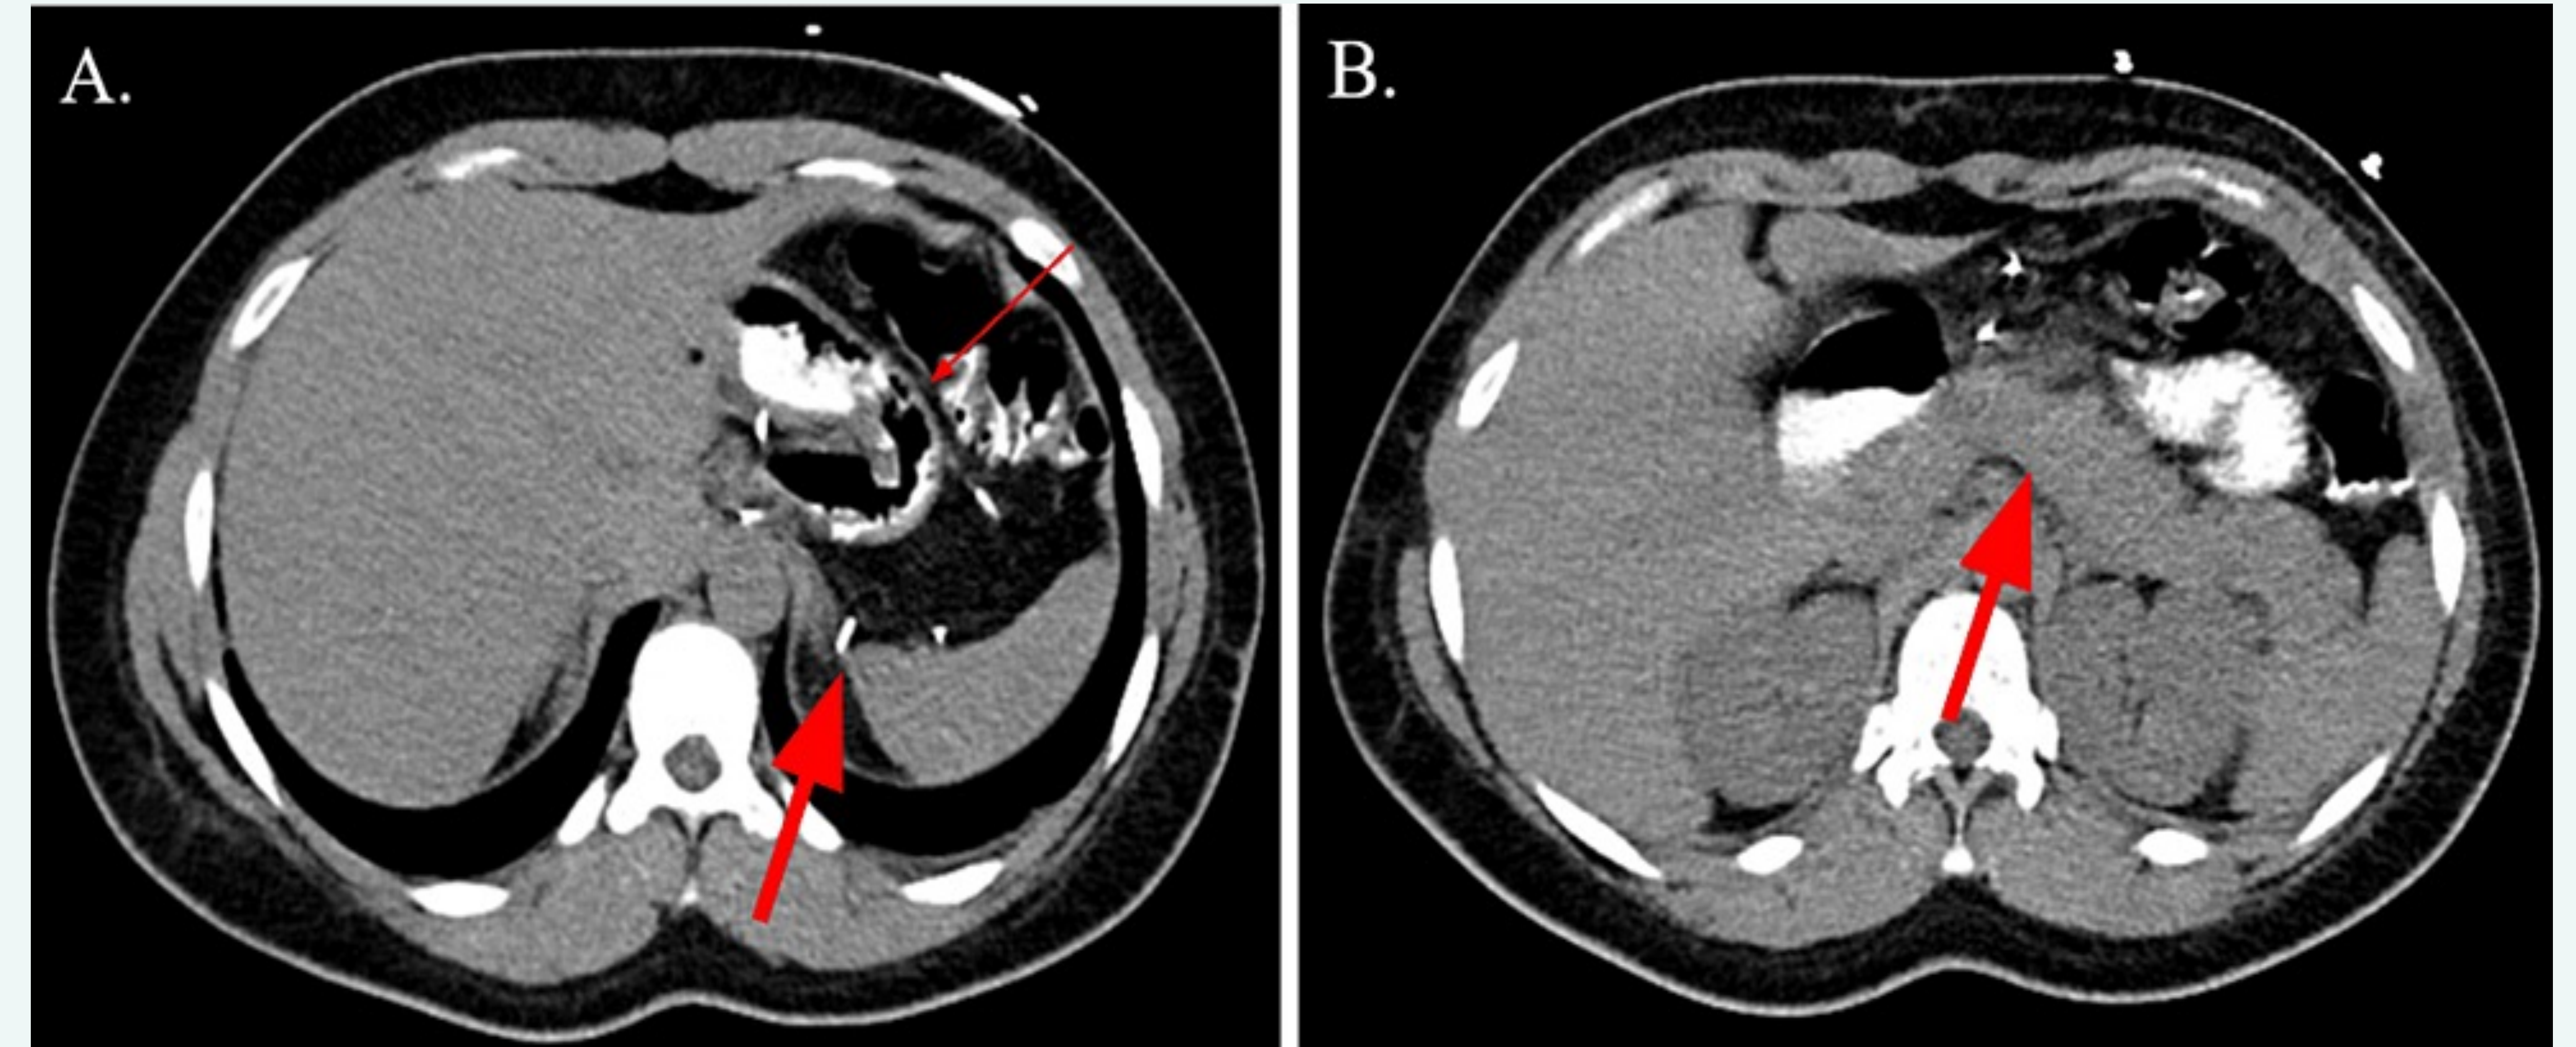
CT Abdomen Pelvis with Oral Contrast Only
